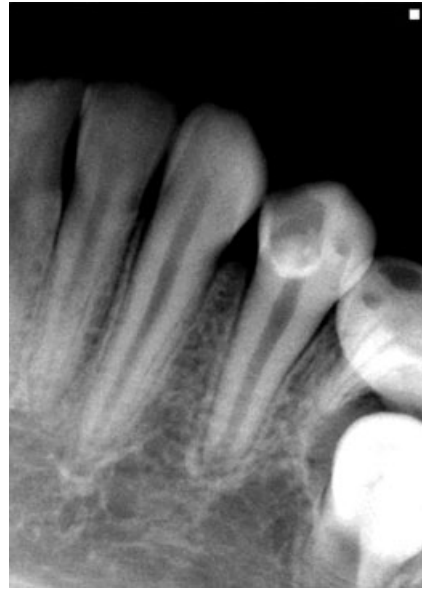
Follow-up periapical radiograph at 4 months presenting with continued root development.
